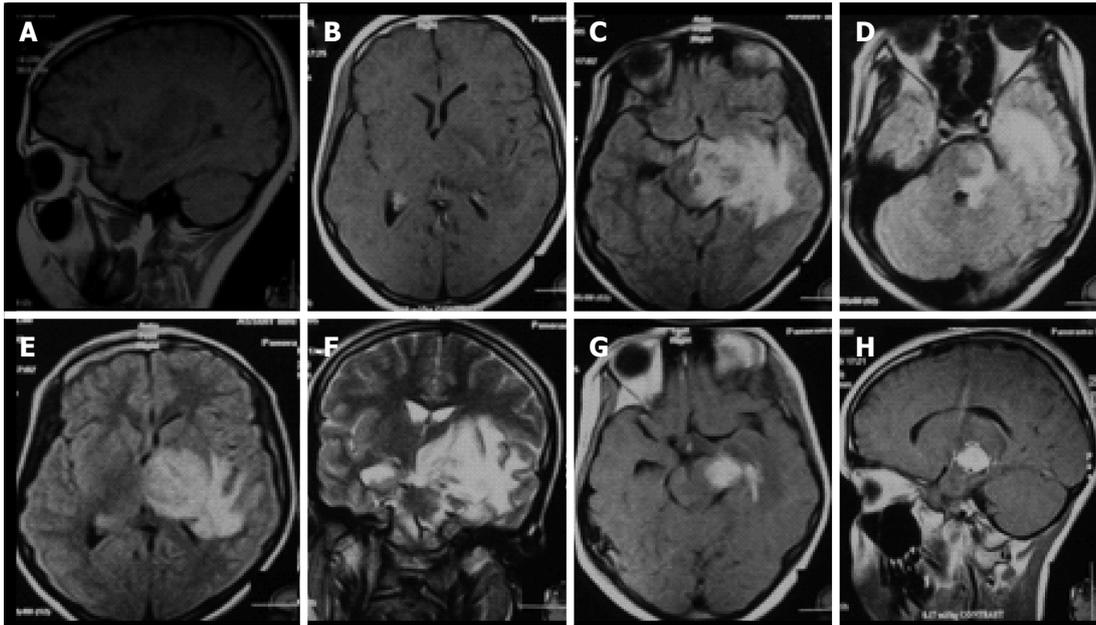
Cranial magnetic resonance imaging brain (on admission at September 2009) showing (A, B) sagittal and axial T1-weighted views with a solitary hypointense lesion in the left temporal lobe; (C-E) axial fluid attenuated inversion recovery and T2-weighted (F) images showing hyperintense lesion in the left temporal lobe encroaching on the adjacent brainstem with perifocal edema and mass effect; (G, H) axial and sagittal T1-weighted views showing homogenous solitary enhanced lesion in the left temporal lobe encroaching on the adjacent brainstem and surrounded by a moderate hypointensity.
